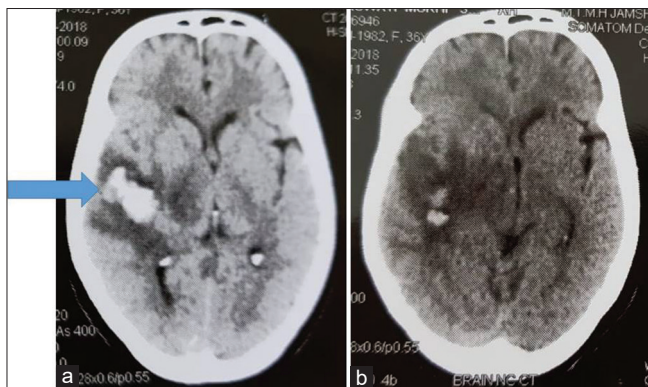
(a and b) Non contrast computed tomography of the brain showing acute bleed in the right parietal lobe with surrounding edema and mass effect (arrow)
